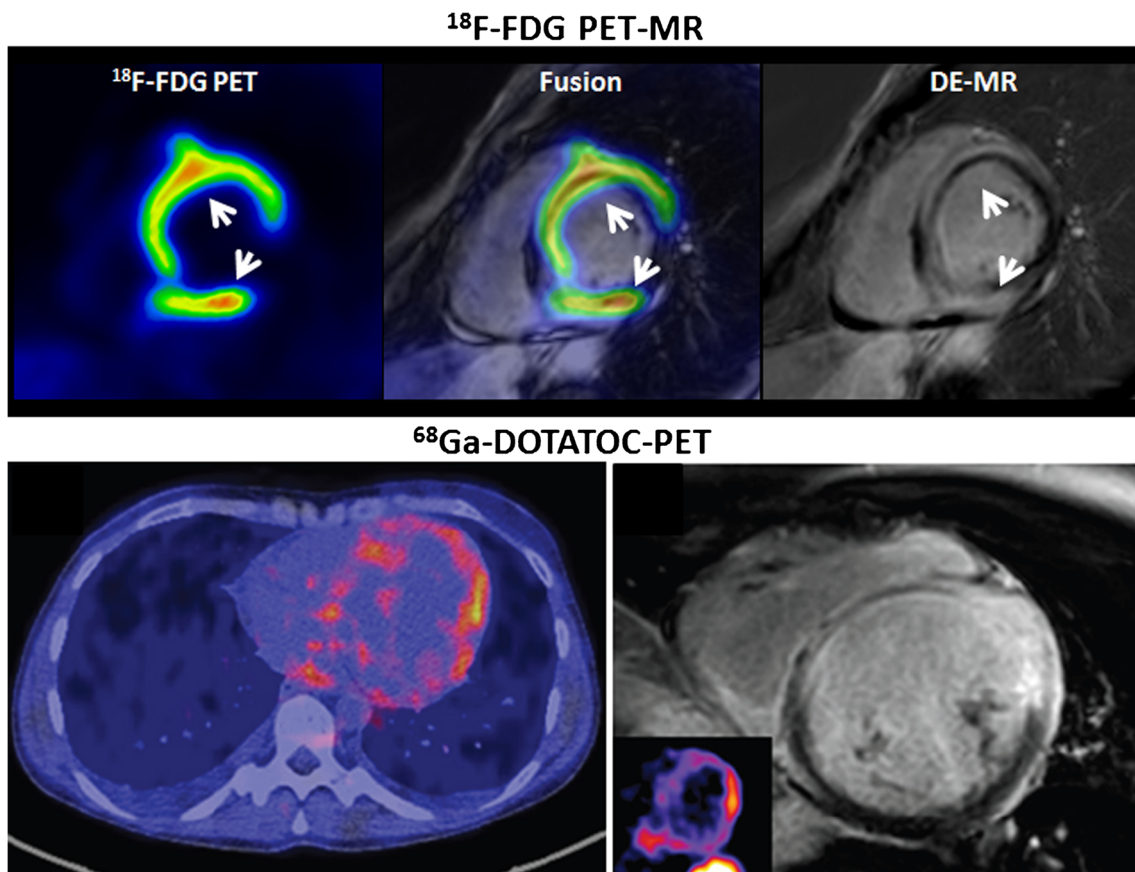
Imaging of myocardial inflammation in cardiac sarcoidosis with combined ^{18}F -FDG PET (*top*) or ^{68}Ga -DOTATOC PET (*bottom*) and delayed-enhancement magnetic resonance (DE-MR). Uptake of PET
